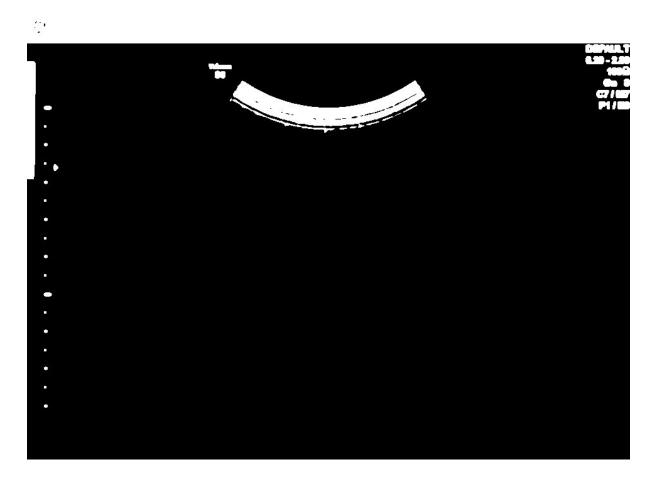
Ultrasound image with thresholding applied at an intensity selected using Otsu's binarization
